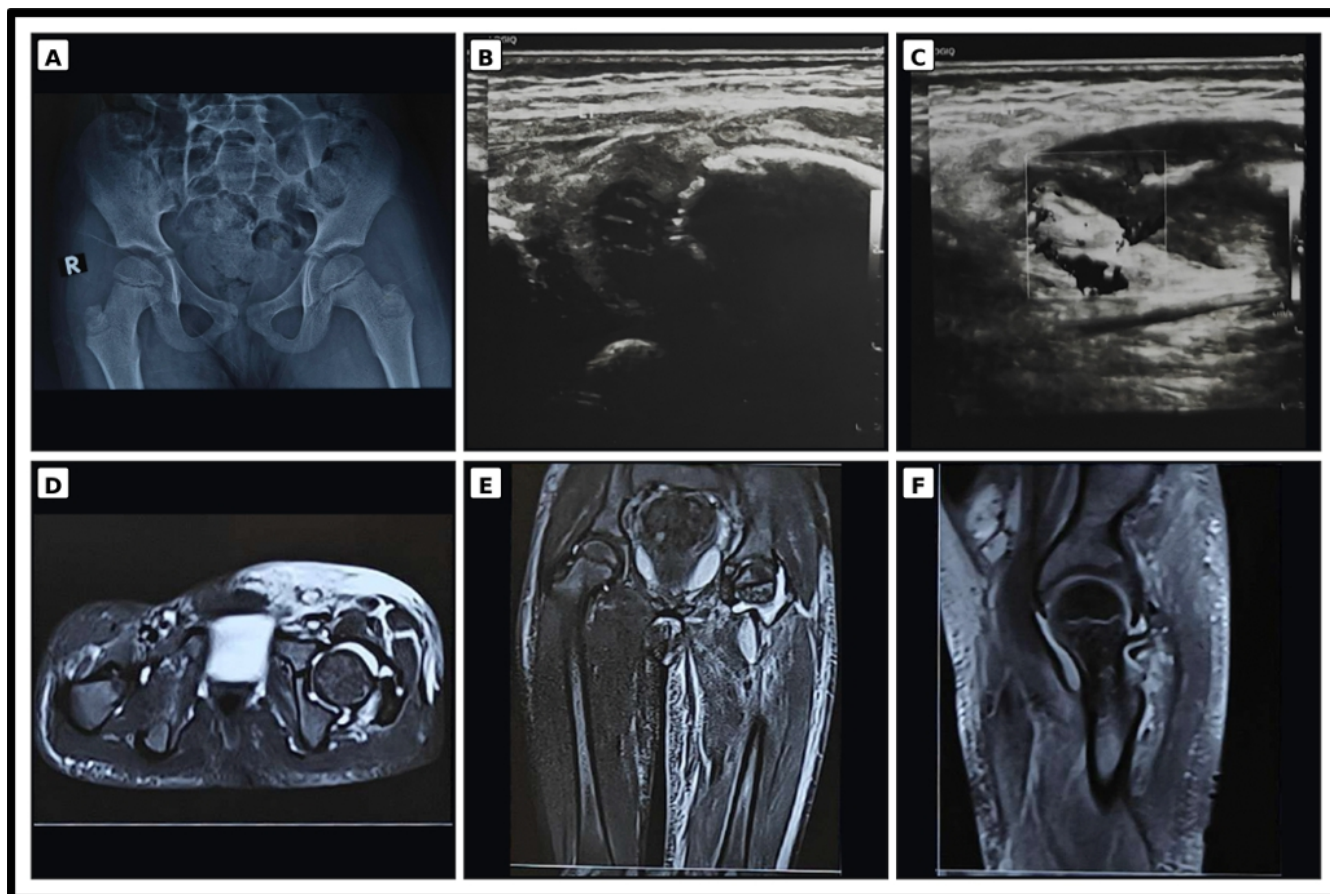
Representative multimodal imaging of a partially treated child with low admission inflammatory markers and operatively confirmed septic arthritis. (a) Anteroposterior pelvic radiograph shows maintained hip alignment without a definite acute osseous abnormality. (b and c) Grayscale and Doppler HRUSG demonstrate capsular distension, complex joint effusion and synovial hyperemia in the symptomatic hip. (d, e, f) Axial, coronal, and sagittal fluid-sensitive MR images confirm hip-joint effusion with synovial and periarticular inflammatory change; no adjacent osseous focus is evident in the displayed sections. Frank intra-articular pus was subsequently documented at open arthrotomy. HRUSG: High-resolution ultrasonography, MRI: Magnetic resonance imaging.
